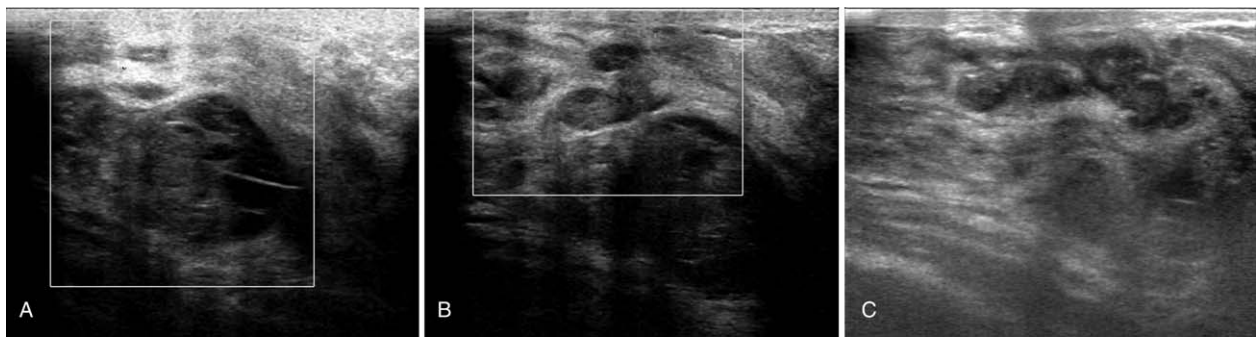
Ultrasonography showed mammary duct ectasia and a solid-cystic mass measured $28 \times 20 \times 20$ mm near NAC of the left breast. NAC = nipple areola complex.
